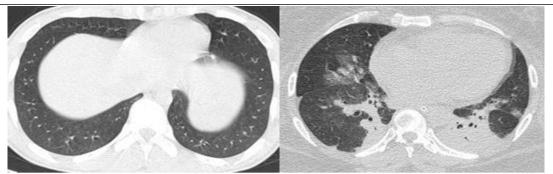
Image on the left is of a 35-year female, Post-COVID infection, and follow up HRCT on 28<sup>th</sup> day - shows normal appearance of bilateral lung fields. The image on the right shows another patient with progression to increased dense consolidations, bilaterally.
